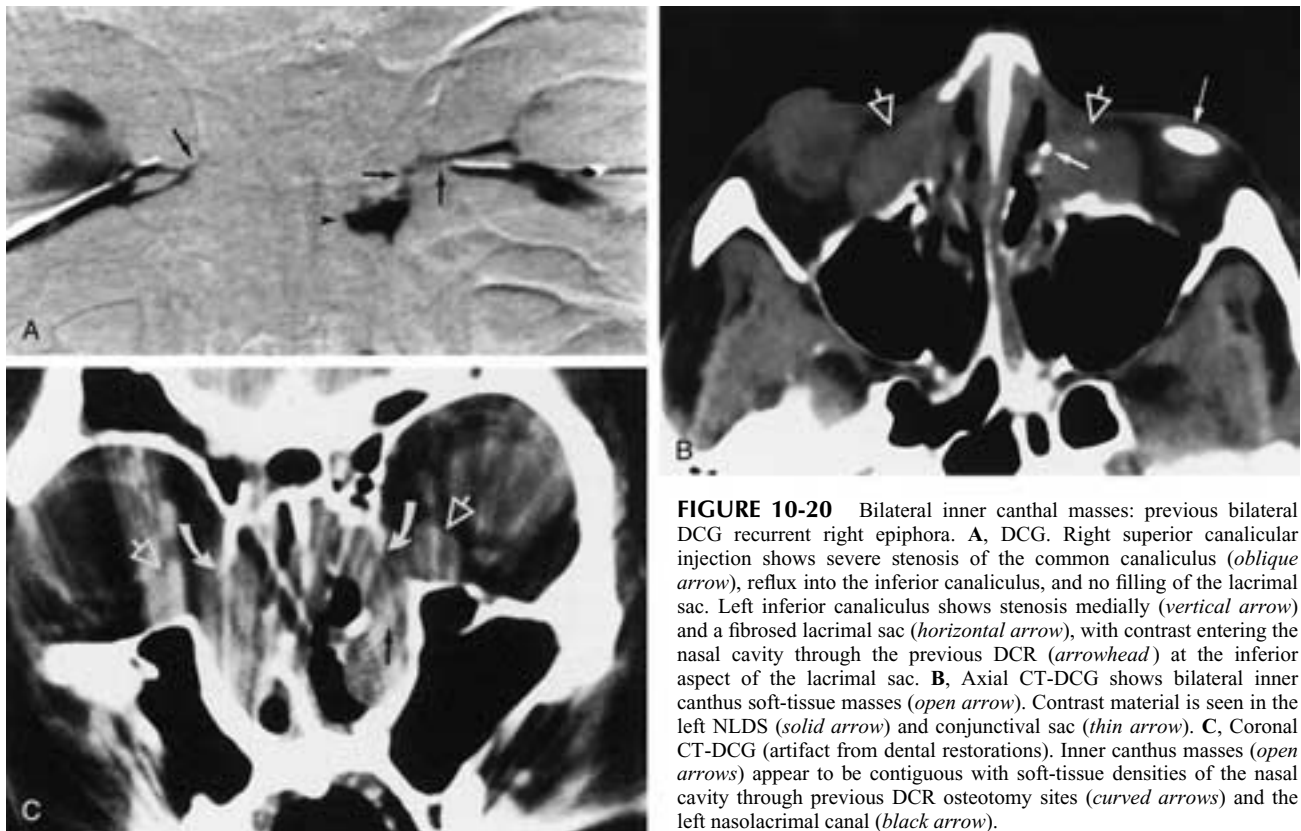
Bilateral inner canthal masses: previous bilateral DCG recurrent right epiphora. A, DCG. Right superior canicular injection shows severe stenosis of the common canaliculus (*oblique arrow*), reflux into the inferior canaliculus, and no filling of the lacrimal sac. Left inferior canaliculus shows stenosis medially (*vertical arrow*) and a fibrosed lacrimal sac (*horizontal arrow*), with contrast entering the nasal cavity through the previous DCR (*arrowhead*) at the inferior aspect of the lacrimal sac. B, Axial CT-DCG shows bilateral inner canthus soft-tissue masses (*open arrow*). Contrast material is seen in the left NLDS (*solid arrow*) and conjunctival sac (*thin arrow*). C, Coronal CT-DCG (artifact from dental restorations). Inner canthus masses (*open arrows*) appear to be contiguous with soft-tissue densities of the nasal cavity through previous DCR osteotomy sites (*curved arrows*) and the left nasolacrimal canal (*black arrow*).
